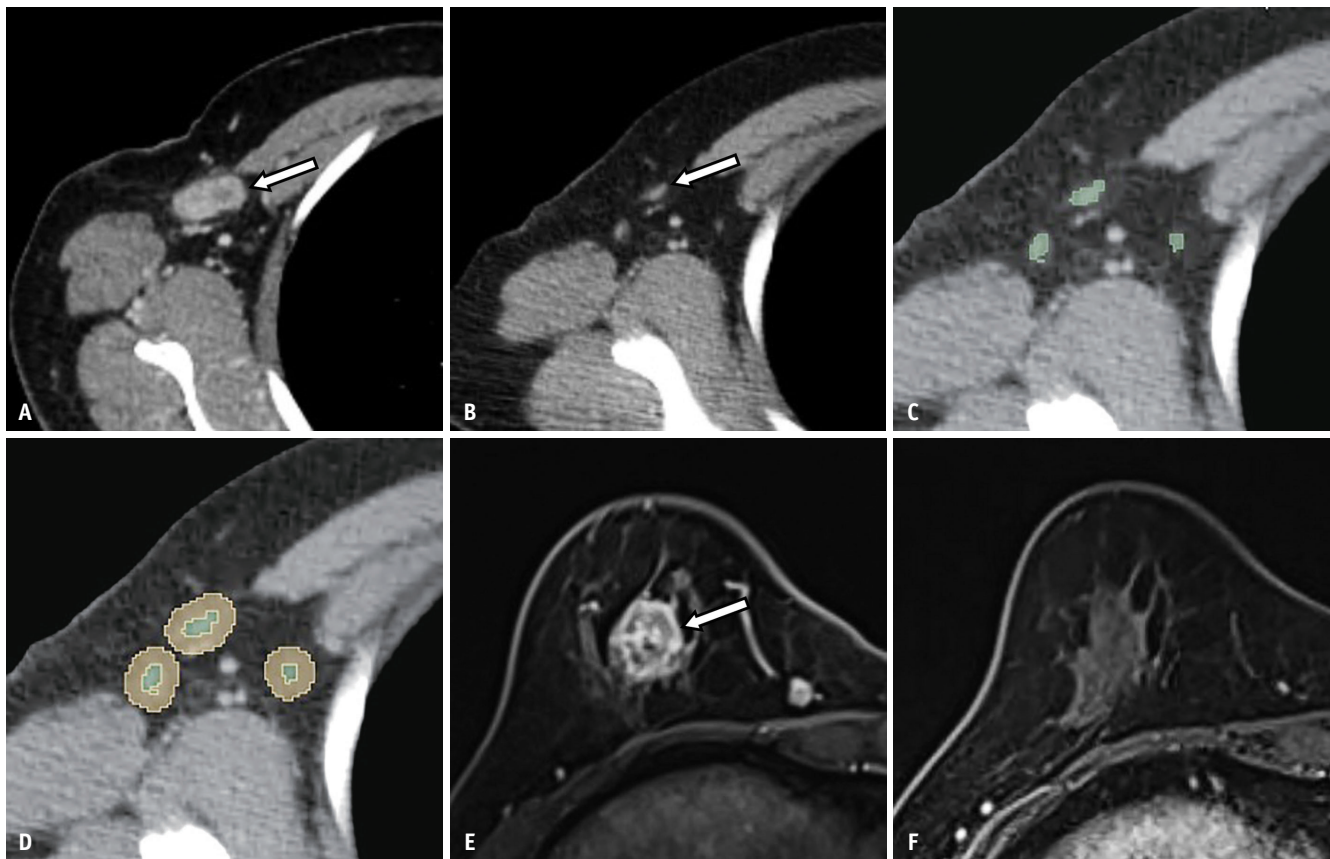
Example of the axillary nodal pathologic complete response and lymph node segmentation. The pre-neoadjuvant chemotherapy (NAC) axial contrast-enhanced computed tomography (CT) image of a 60-year-old woman shows a metastatic lymph node (arrow in A) at the level I right axillary lymph node. The lymph node shows heterogeneous enhancement, and the short-axis diameter of the largest node is 16 mm. The post-NAC CT image shows a decrease in the size of the lymph node without visible heterogeneous enhancement (arrow in B). Green and yellow in (C) and (D) represent the intranodal and perinodal regions of interest in the post-NAC CT images, respectively. The pre-NAC magnetic resonance imaging (MRI) image (E) and post-NAC MRI image (F) show the radiological complete response of primary breast cancer in the right breast (arrow in E). The final pathologic result after axillary surgery indicated the pathologic complete response of the axillary node.
